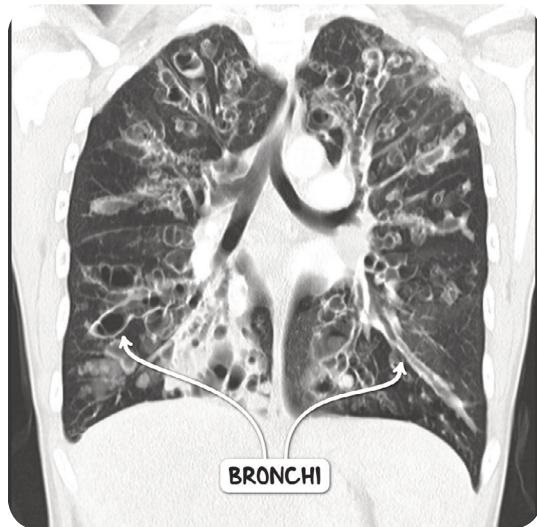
A CT scan of the chest in the coronal plane demonstrating bilateral widespread bronchiectasis in a twenty five year old female with cystic fibrosis.
